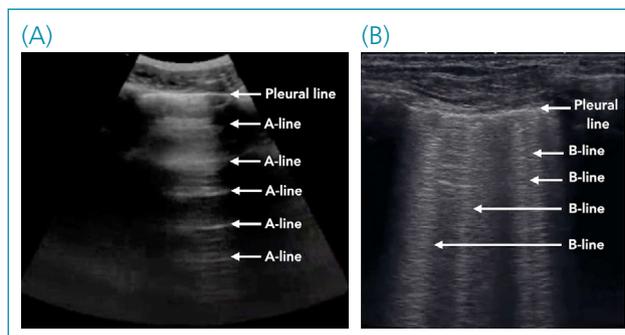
(A) Lung ultrasound showing the pleural line and the artifact A-line and (B) Lung ultrasound displaying the artifact B-line.
